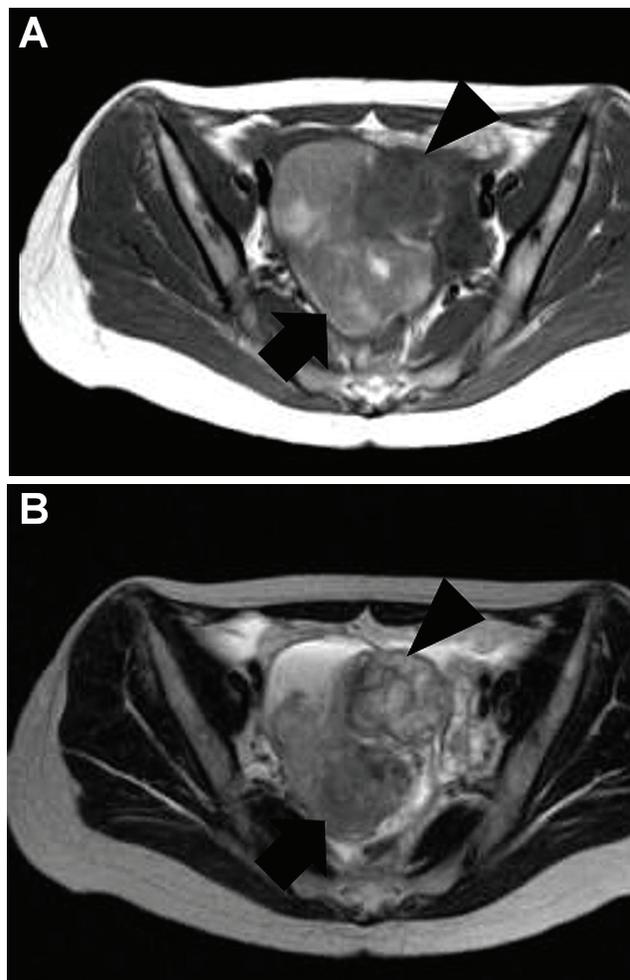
Magnetic resonance image of patient's pelvis at admission. A right adnexal cystic mass, 9.8×9.1×6.0 cm, containing fluid or bloody components (arrow) and a solid tumour (arrow head), 4.5×3.5×3 cm, in the cyst is suggestive of malignancy (A) T1-weighted image. (B) T2-weighted image.
